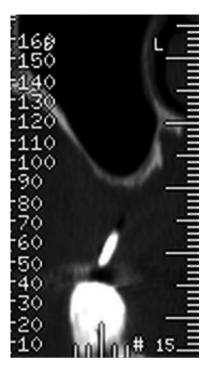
Pre-op CT scan, test side.
